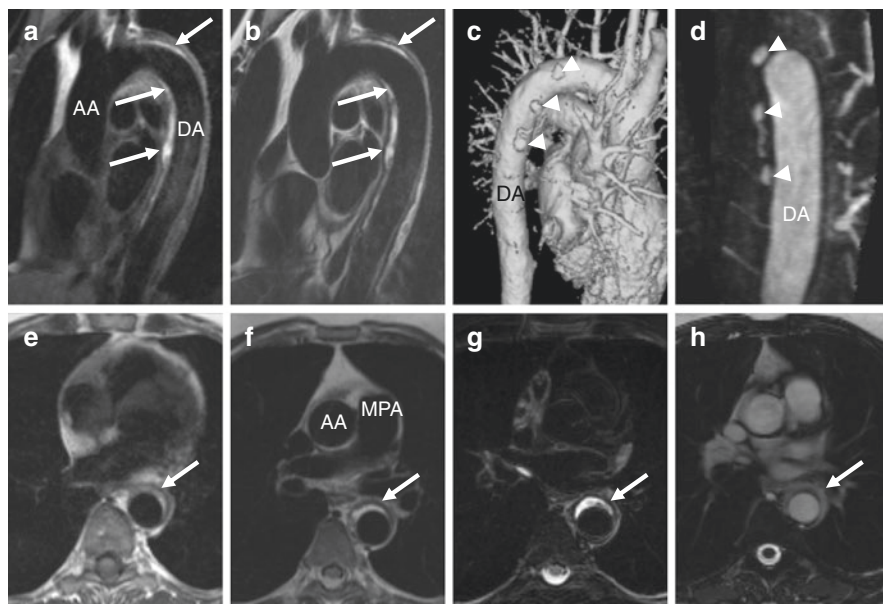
Same patient as in Fig. 8. Candy cane (a & b) and transaxial (e-h) magnetic resonance images using T1-weighted fast spin echo (FSE) with fat saturation (FS) (a) without FS (e), T2-weighted FSE without (b & f) and with FS (g), and a single frame from a cine acquisition using steady-state free precession (SSFP) (h). In addition shaded surface display (SSD) (c) and maximum intensity projection (MIP) images (d) from an MR angiogram are shown. Arrows identify IMH in the descending thoracic aorta. Bright signal on both T1- and T2-weighted images indicated blood products chiefly in the extracellular methemoglobin phase consistent with a subacute to chronic lesion. Small outpouchings seen on the MRA images (arrowheads) represent intramural blood pools (IBP) that are pseudoaneurysms of small branching vessels, in this case intercostal arteries, within the aortic wall. When multiple IBPs are present the appearance resembles a so-called Chinese ring-sword. AA Ascending aorta; DA Descending aorta; MPA Main pulmonary artery
